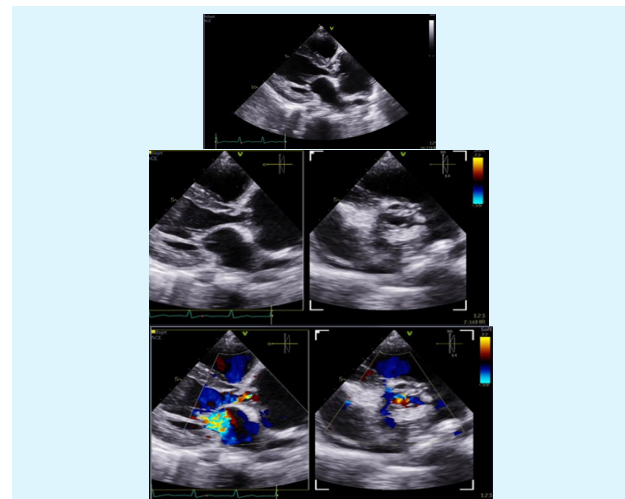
Transthoracic echocardiography -parasternal views.
